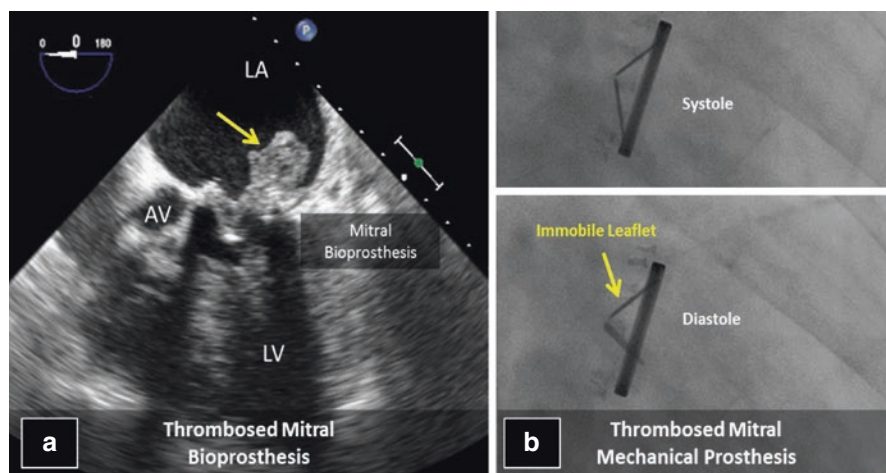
Prosthetic valves. (a) Thrombosis on mitral valve bioprosthesis visualized on TEE. (b) Mechanical valve thrombosis on cinefluoroscopy demonstrating impaired leaflet mobility during diastole leading to impaired flow (*bottom image*). Normal systolic leaflet closure is maintained (*upper image*). LA Left atrium, AV Aortic valve, LV Left ventricle, TEE Transesophageal echocardiogram
